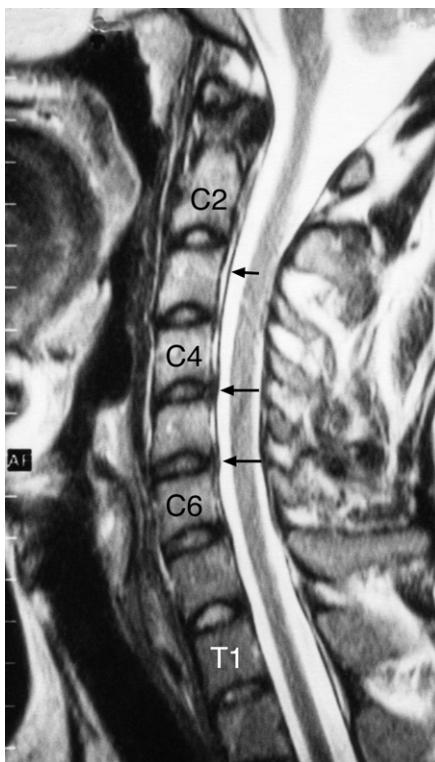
Cervical spine MRI sagittal T2-weighted image. Note the small posterior disc bulges (black arrows) at C4–5 and C5–6 that press on the pain sensitive anterior surface of the dural tube (small black arrows). There is early desiccation of some of the discs.
